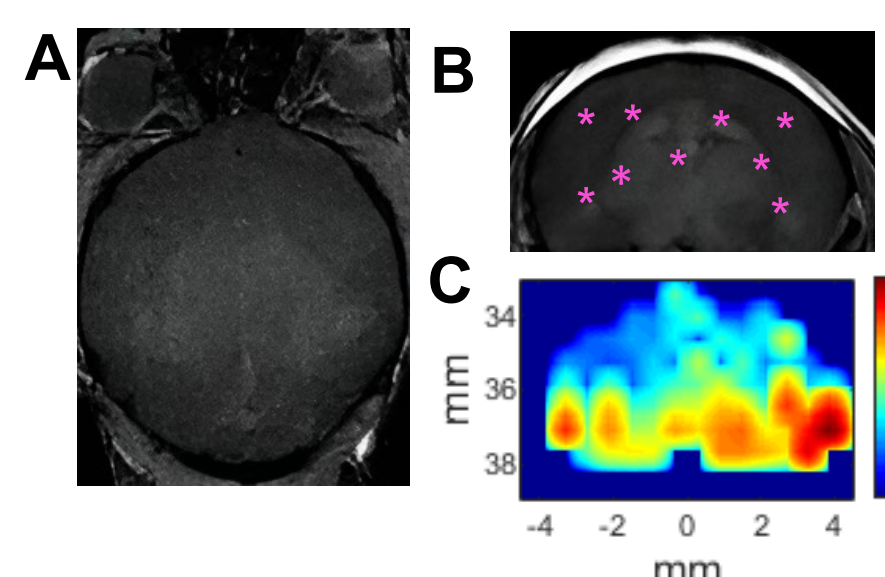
ThUS multi focus protocol. Axial (A) and coronal (B) Contrast-enhanced T₁-weighted MRI depicting locations of focal regions. C) Whole-brain cavitation mapping with power cavitation imaging (PCI)
